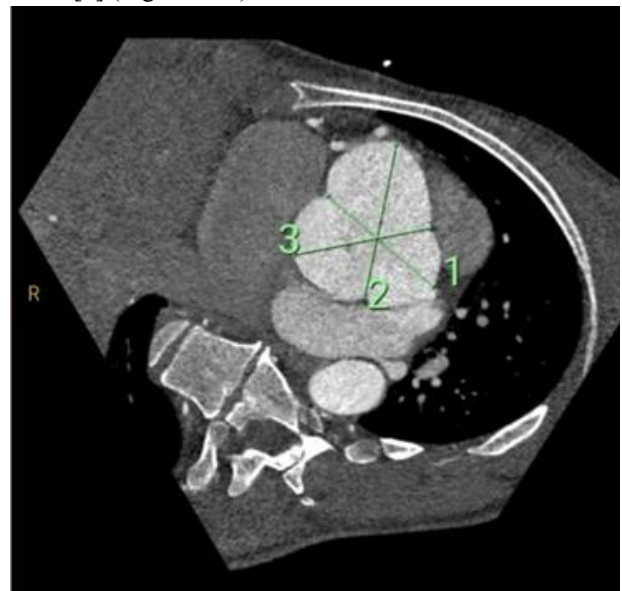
CT aortogram demonstrating severe aneurysmal dilatation of the aortic root at the level of the sinuses of Valsalva.
